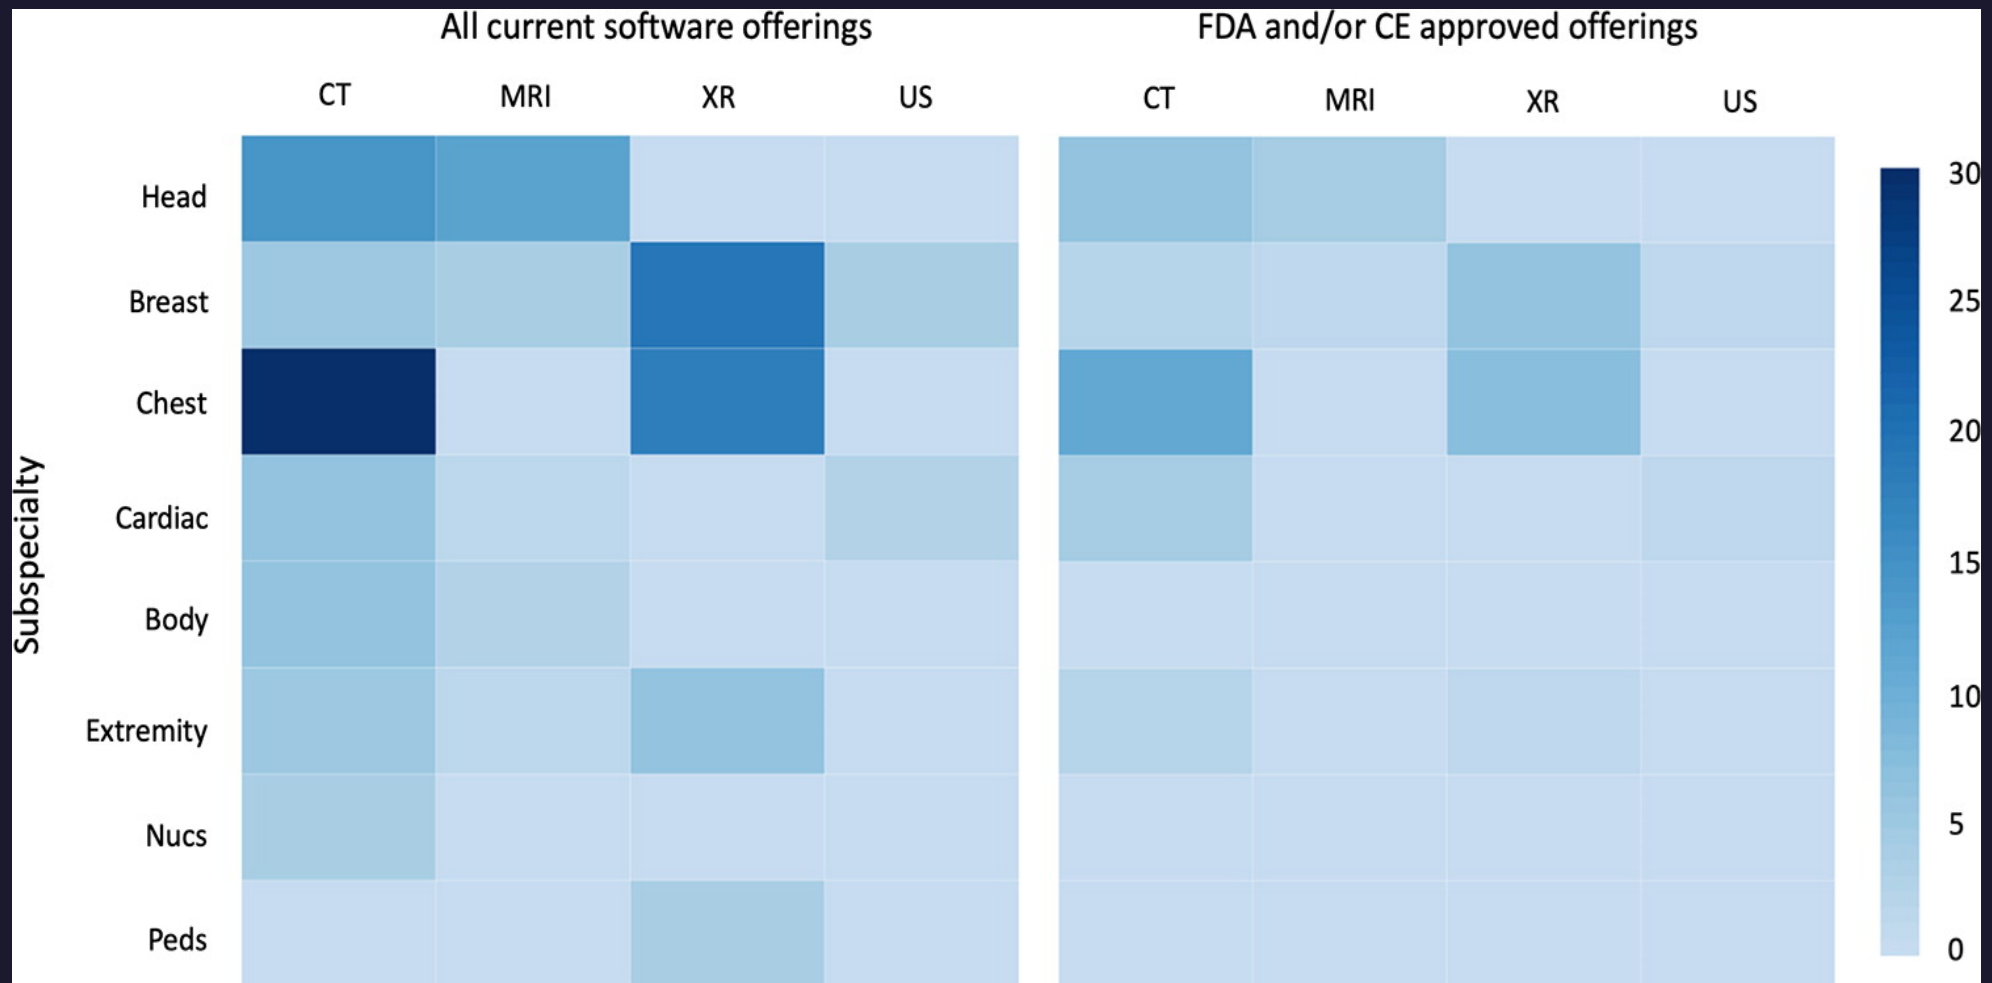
Distribution of current radiology artificial intelligence (AI) software offerings. The left panel represents the frequency of all radiology AI software offerings by subspecialty and modality, whereas the right panel demonstrates only those with Food and Drug Administration (FDA) and/or Conformité Européenne (CE) mark of approval at the time of writing (November 2019). Nuc = nuclear medicine, Peds = pediatric, XR = radiography.
